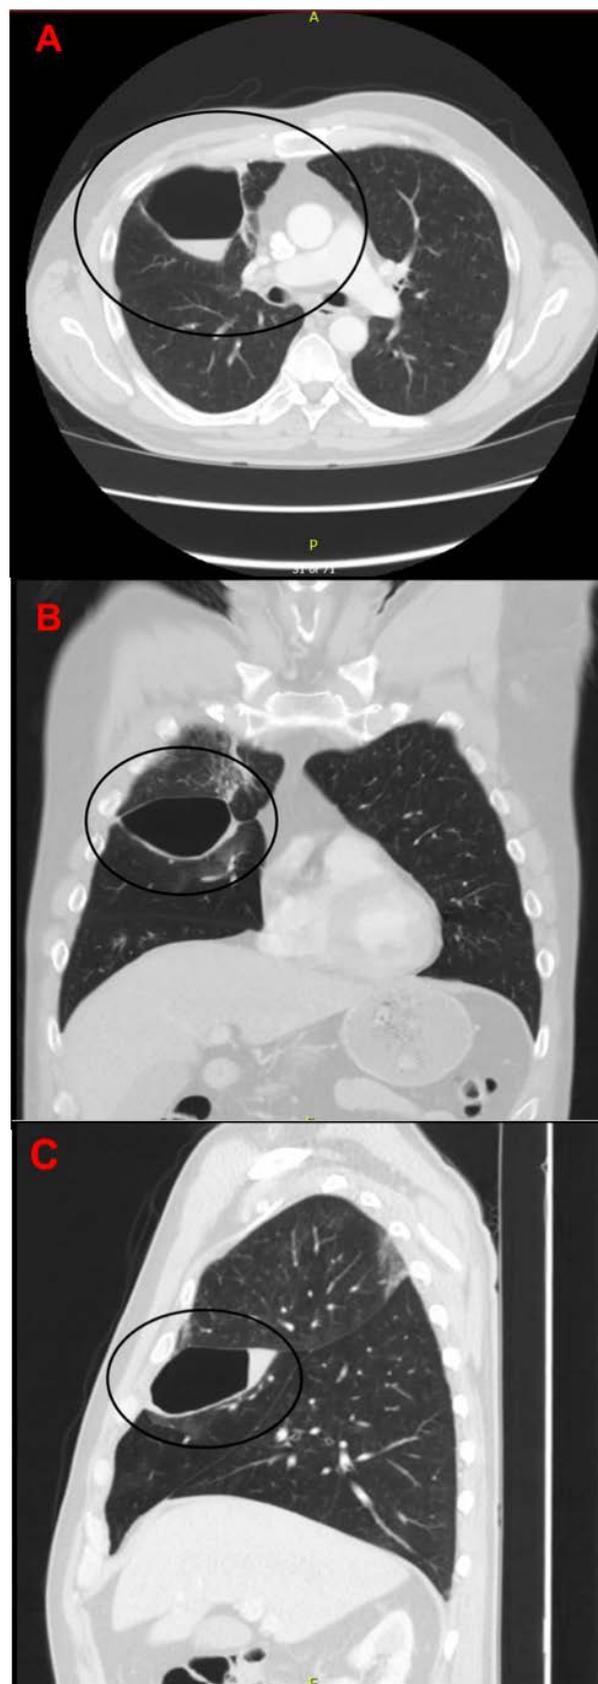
Admission chest computed tomography of Panel A) Coronal view, Panel B) Axial view, Panel C) Sagittal view. Cavitary lung lesion in the right middle lobe with thin-walled lucency and an air-fluid level, measuring 8.0 x 4.9 cm, indicated by the circle. No emphysematous changes or infiltrates seen.
